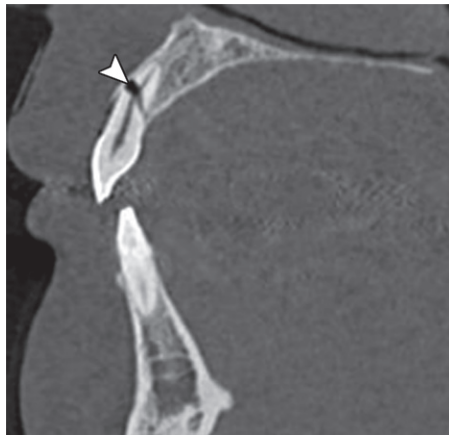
Dental root fracture. Sagittal CT image (bone window) shows a root fracture with pulp involvement (arrowhead).
